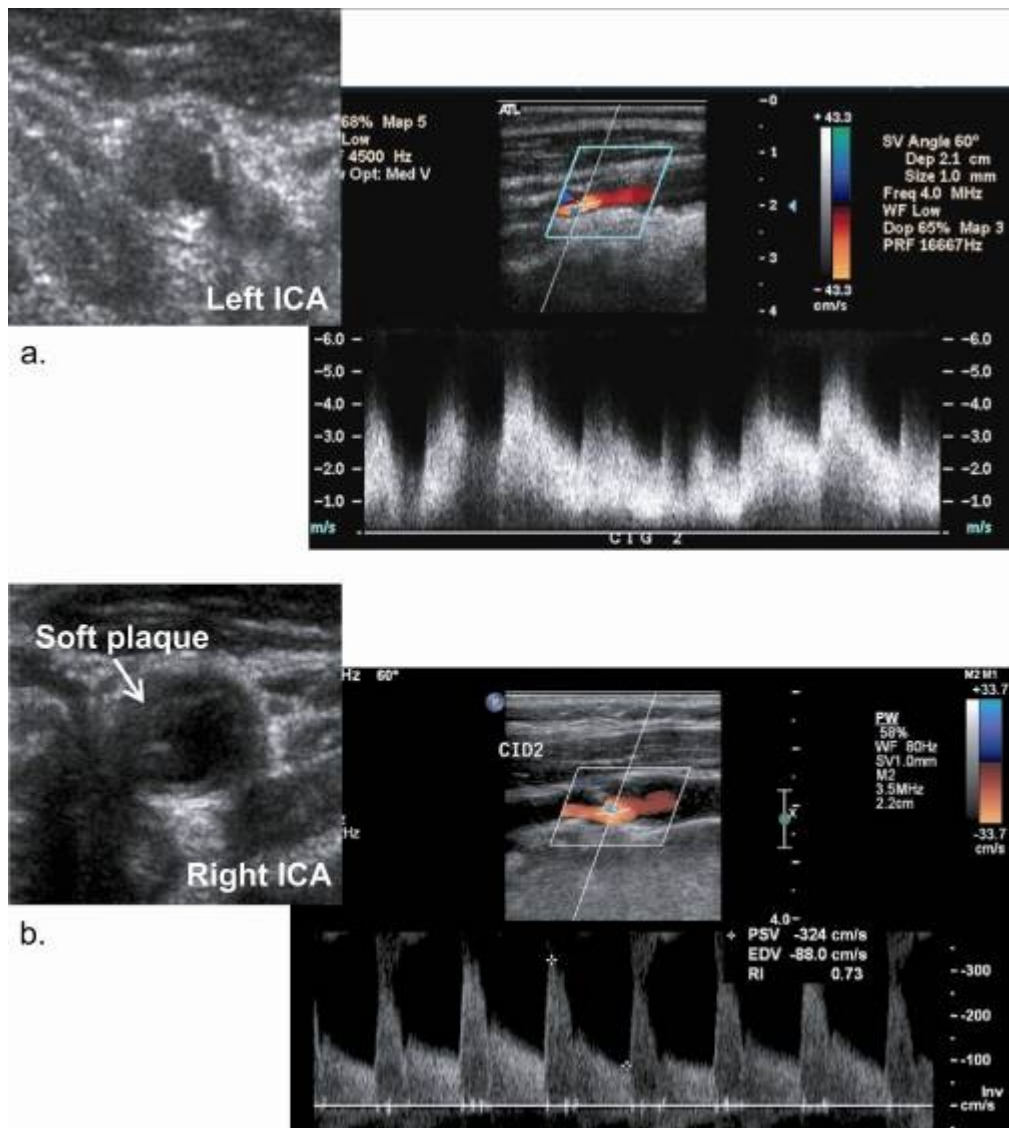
Doppler ultrasound of carotid arteries of a 46-year-old woman with hypercholesterolemia and transient cerebral ischemia of the right middle cerebral territory. (a) Significant stenosis of the left internal carotid artery from an echogenic homogeneous plaque that narrows the vessel lumen. (b) 80% right internal carotid artery stenosis (in diameter reduction, according to criteria from [76]). The stenotic plaque is echolucent (soft plaque) likely because of its high lipid content, haemorrhage and low calcium content.
